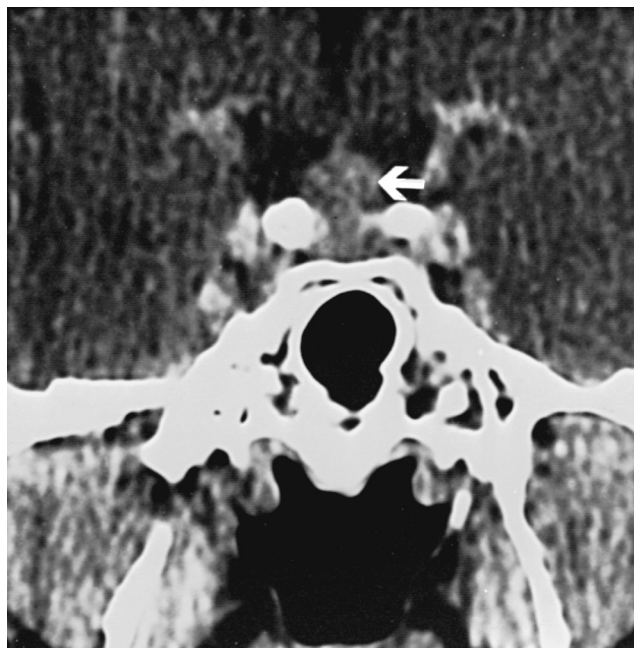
Typical close-up coronal view of a pituitary microadenoma by computed tomography (CT). The neoplasm cannot be distinguished from normal pituitary. Thus the arrow indicates an enlarged abnormal pituitary bulging superiorly. The stalk is seen superior to the gland in the midline. The bone appears white on CT scan. Magnetic resonance imaging may allow better resolution of neoplasms from normal pituitary. (Modified from Rebar RW: Practical evaluation of hormonal status. In Yen SC, Jaffe RB, Barbieri RL, editors: Reproductive endocrinology, physiology, pathophysiology, and clinical management, ed 4, Philadelphia, 1999, WB Saunders, p 709.)
